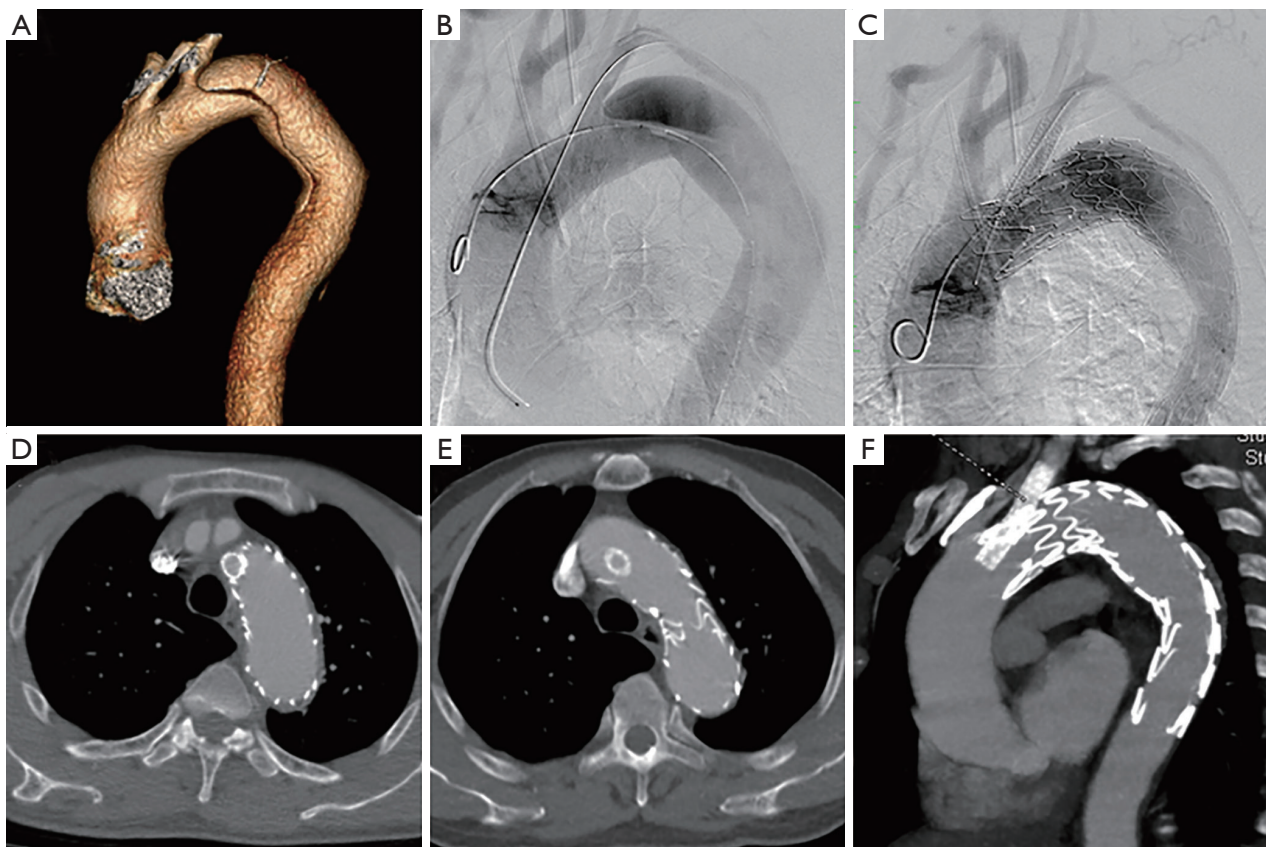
One patient underwent TEVAR with concomitant revascularization of LSA using the chimney stent. (A) Preoperative three-dimensional reconstruction CTA showed an aortic dissection of which the tear was close to the LSA orifice; (B) intraoperative angiogram; (C) the completion angiogram showed that one chimney stent was placed in the LSA without immediate endoleak; (D) follow-up CTA at 1 year showed the patent chimney stent with no endoleak; (E,F) follow-up CTA at 3 years showed the patent chimney stent with no endoleak. CTA, computed tomography angiogram; LSA, left subclavian artery.
